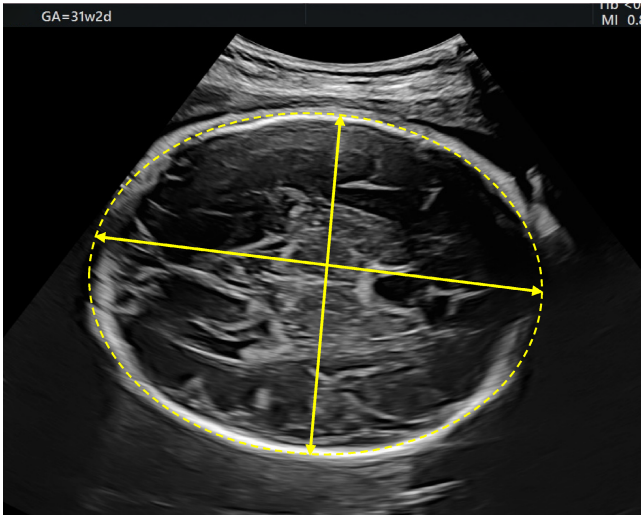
Sonographic measurement of fetal head circumference in third trimester.
